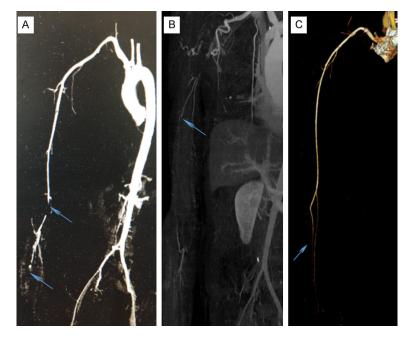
Follow-up CTA results of patient 1, 4, and 5. A: The 48th month postoperative CTA showed that multiple arterial thrombosis (arrow). B: The 12th month CTA revealed an establishment of collateral circulation in patient 4. C: The CTA results of 24th month demonstrated a poor filling in distal side of radial artery (patient 5).
